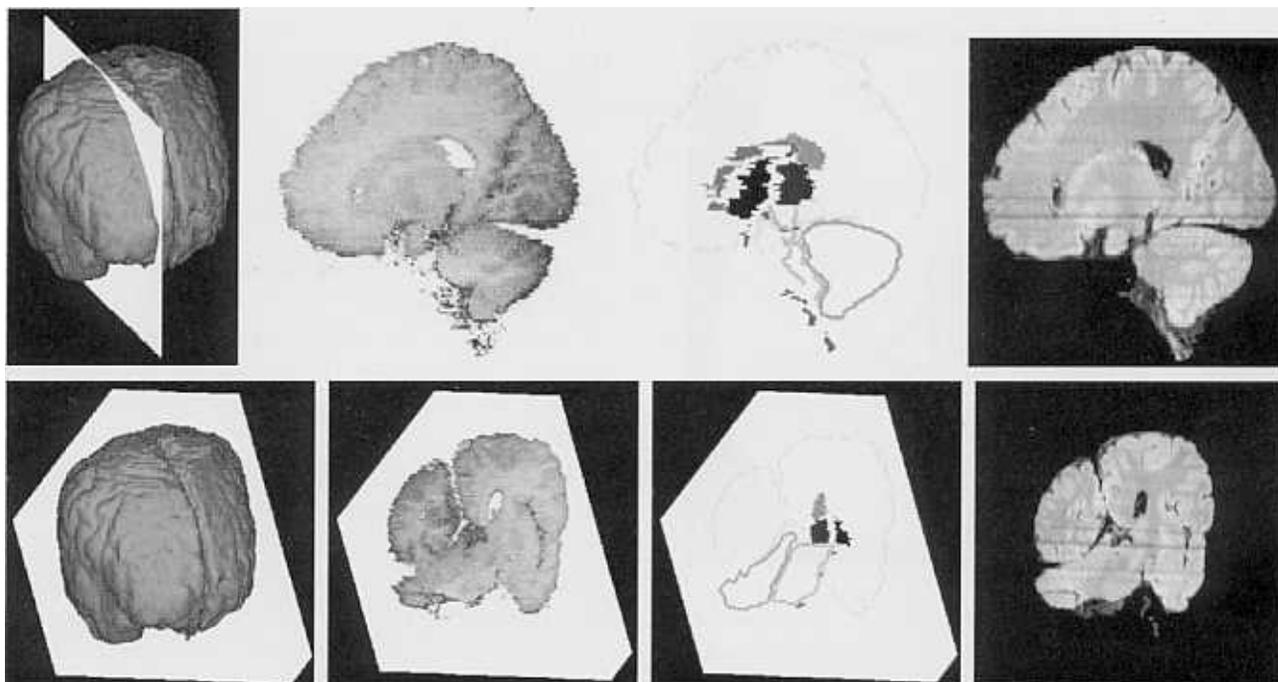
Sagittal sectioning (top row) and free angle sectioning (bottom row) of 3D images of the brain, followed by their planes represented as real images (second column), segmented images (third column), and MRI (fourth column).
